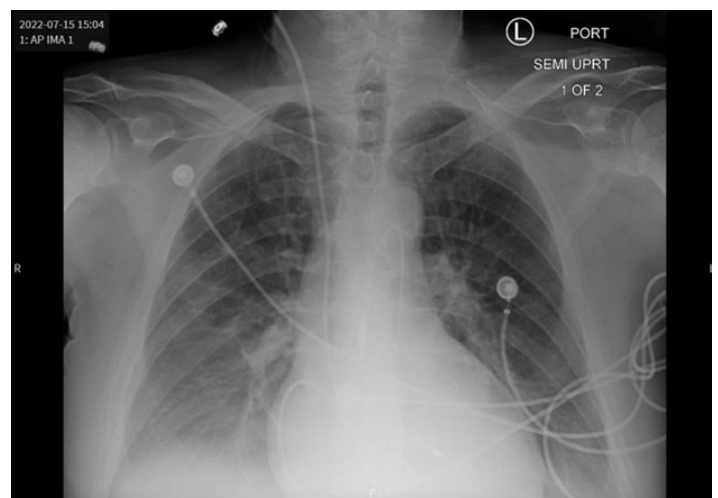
Chest X-Ray with Cardiomegaly.
